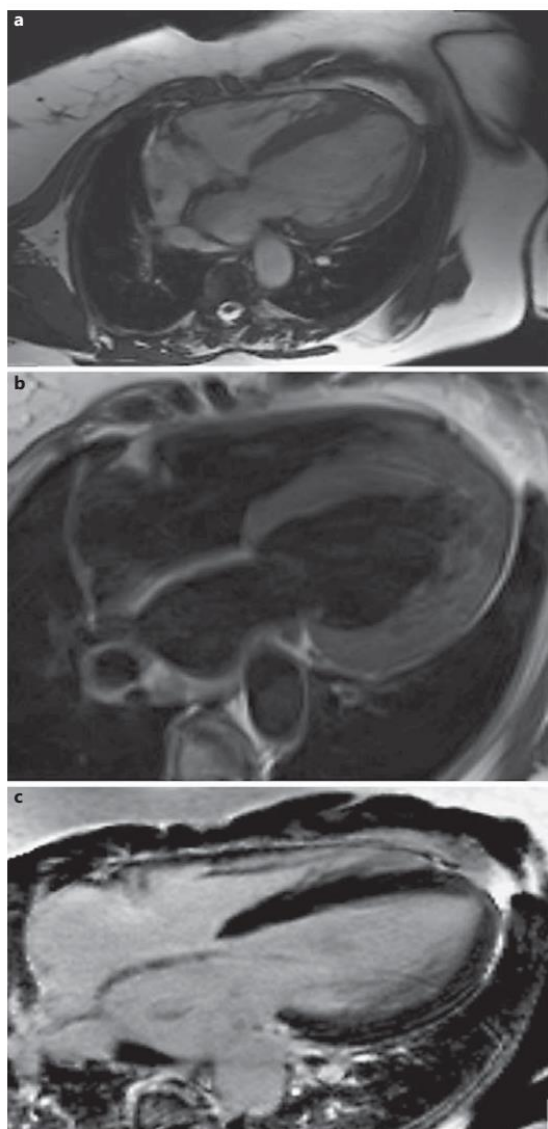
a MR cine image showing dilatation of the left ventricle. b T2-weighted inversion recovery MR image with no signs of myocardial oedema. c Late gadolinium MR image showing no delayed enhancement.
